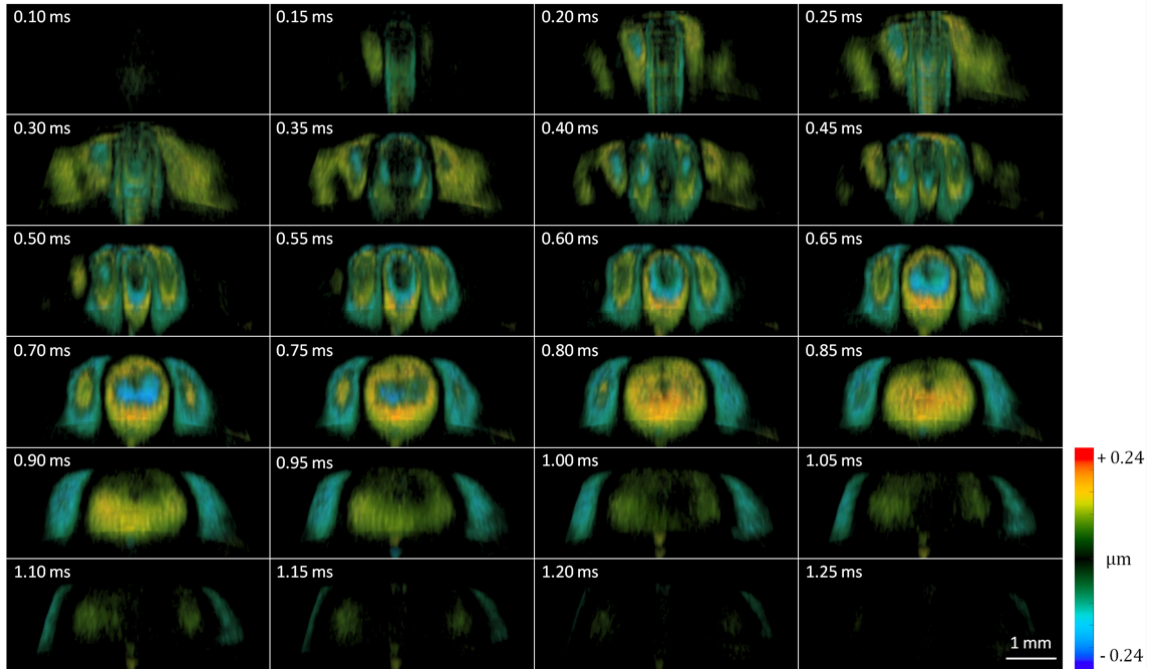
Time-lapse 3D Doppler OCT of the 12-week-old rabbit lens.
